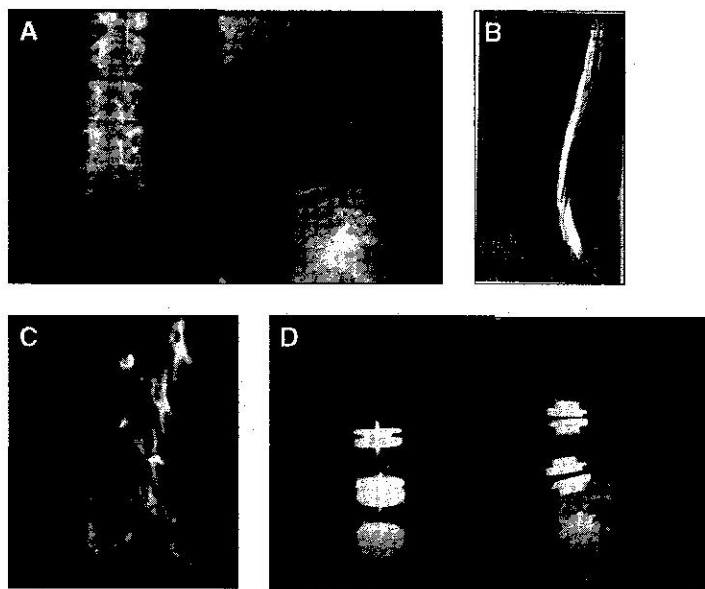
Case 3 preoperative radiographs (A), MRI (B), and CT discogram (C), and postoperative anteroposterior and lateral radiographs (D).
